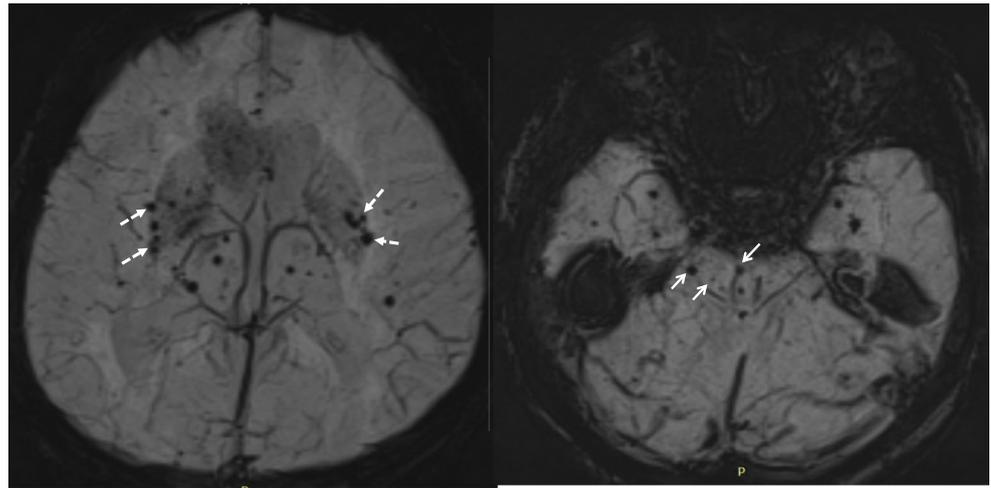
Cranial MRI showing bilateral, multiple, T2 hyperintense lesions in the periventricular areas, subcortical white matter and basal ganglia (arrows) (a). Susceptibility-weighted imaging showing multiple microhemorrhages in the bilateral basal ganglia and brain stem (b). T1 sequences (c)
